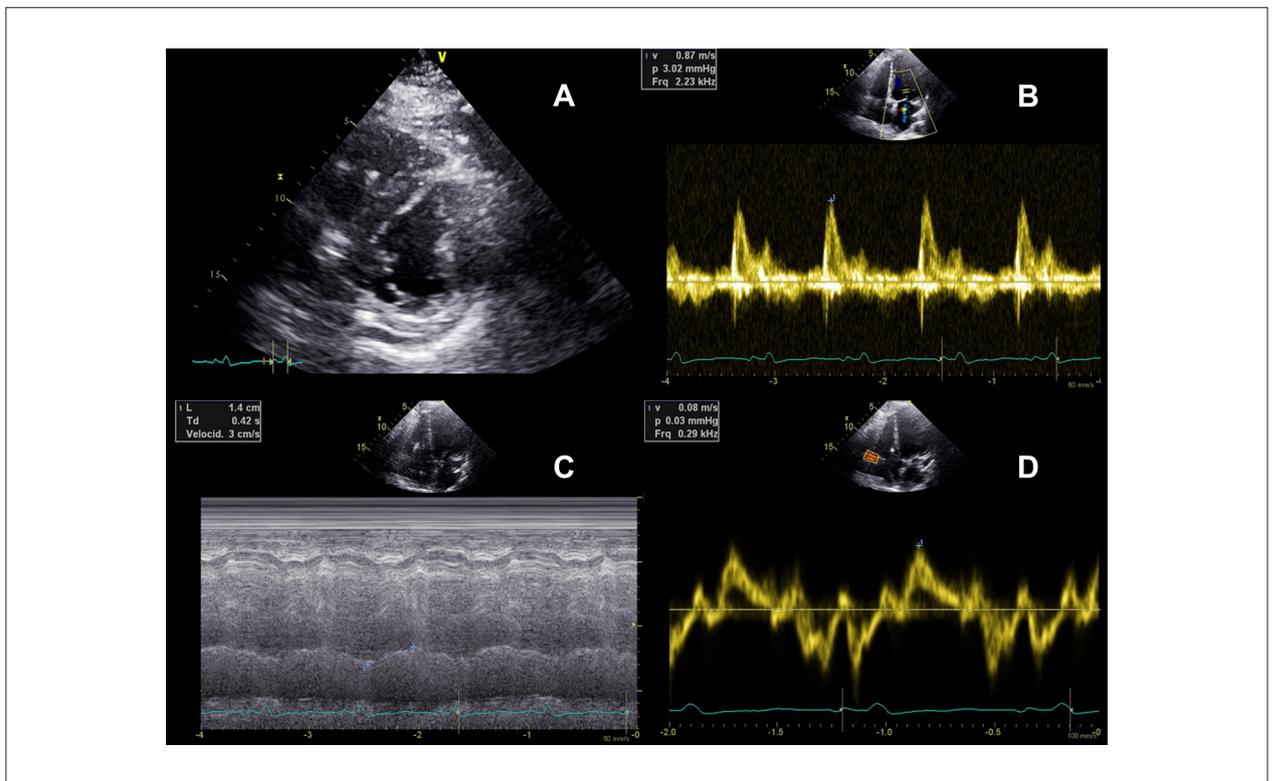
Images in the transthoracic echocardiography of patient with cardiac sarcoidosis. There is rectification of the ventricular septum, in the cross-sectional parasternal view, due to pressure overload and pulmonary hypertension, besides mild pericardial effusion in cross-sectional parasternal view (A). There are signs of diastolic function in mitral Doppler, with E/A ratio > 2, and shortened time of deceleration (B), besides systolic dysfunction of the right ventricle, assessed by the reduced tricuspid annular plane systolic excursion (TAPSE = 14 mm; abnormal if < 16 mm), and reduced s' wave of the right ventricular free wall (s' wave = 8 mm/s; abnormal if < 9,5 mm/s).
